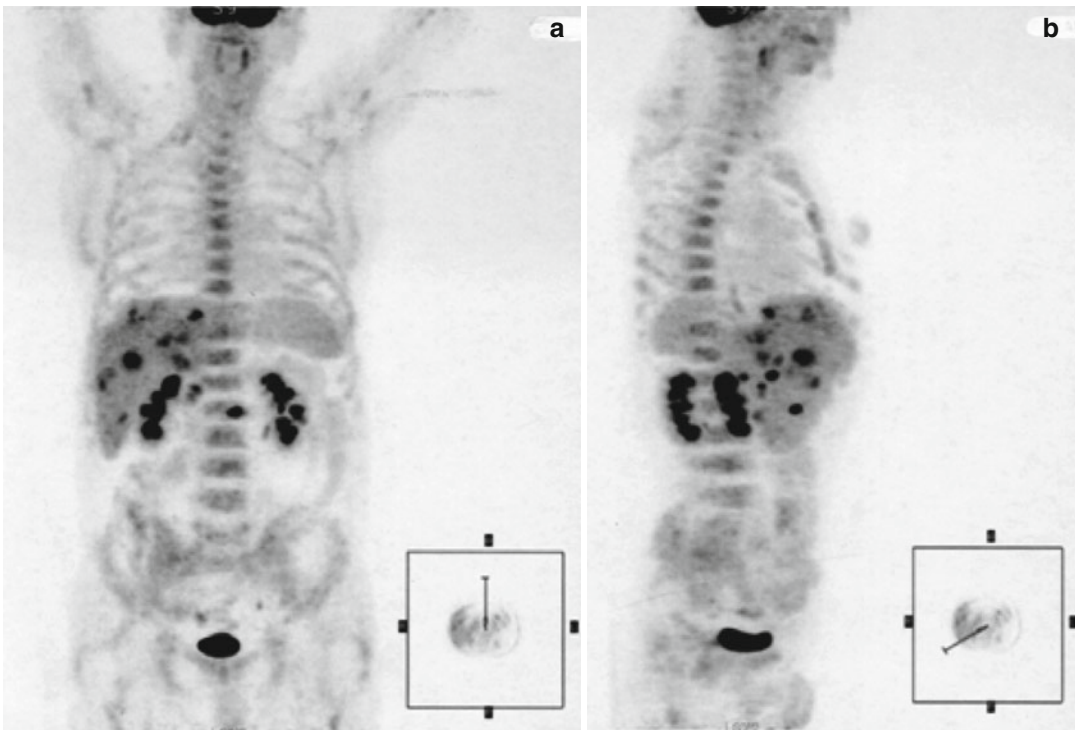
(a, b) Anterior (a) and lateral (b) views of maximum intensity projection FDG PET image show multiple foci of abnormal metabolic activity in the abdomen and diffuse FDG uptake in the bone marrow
